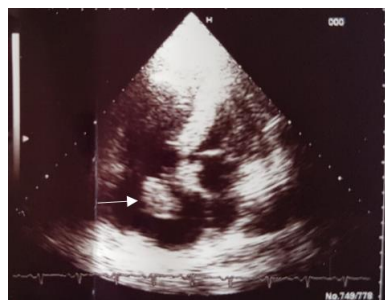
and Figure 4: Transthoracic two-dimensional echocardiography showing a voluminous right intra-auricular mobile thrombus and dilatation of right cavities
